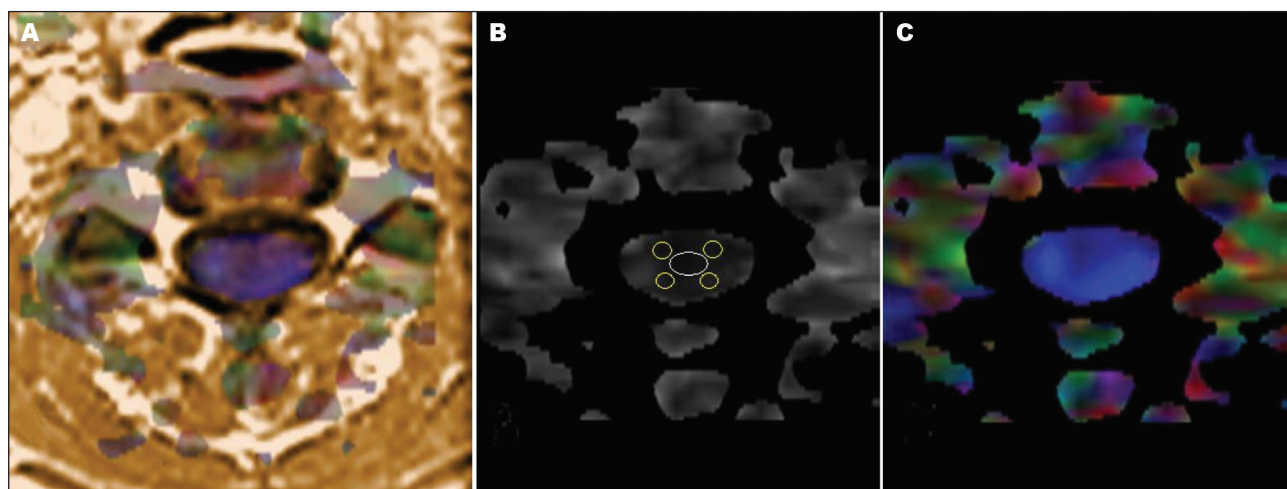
28-year-old female patient with MS. Cervical spine MRI showing axial T1 fused with FA color map [A], FA map [B] and FA color map [C]. In B, the position of the ROIs is demonstrated. An ROI was drawn in the center of the spinal cord (white) for guiding the placement of the ROIs in the right anterior, right posterior, left anterior and left posterior horns (yellow) of the spinal cord.
